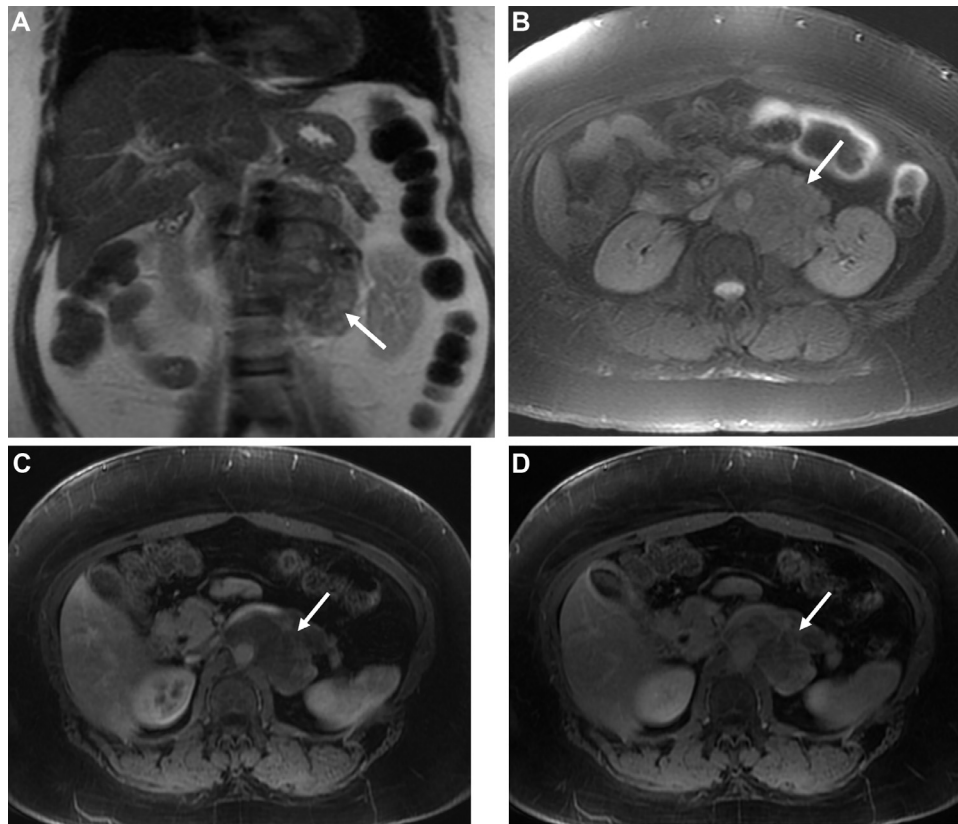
(A) Coronal T2-weighted MR and (B) axial fat-saturated T2-weighted MR images also demonstrate a lobulated left retroperitoneal mass with intermediate heterogeneous signal intensity (arrows) and vascular encasement. (C-D) Axial postcontrast T1-weighted MR in the arterial phase (C) and portal venous phase (D) show heterogeneous progressive enhancement of the left retroperitoneal mass (arrows).
